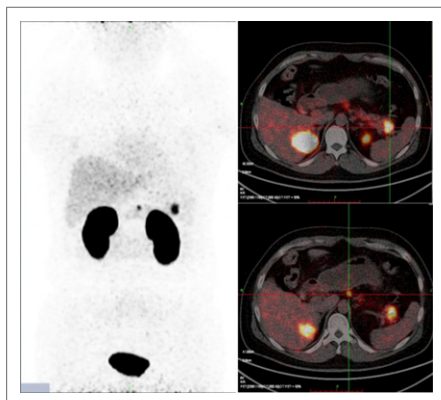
^{68}Ga -exendin-4 PET/CT localization of insulinomas in a 37-y-old man with a 6-mo history of neuroglycopenia. Somatostatin receptor scintigraphy (left) was positive in the pancreatic tail but negative in the body. A 30-min ^{68}Ga -exendin-4
